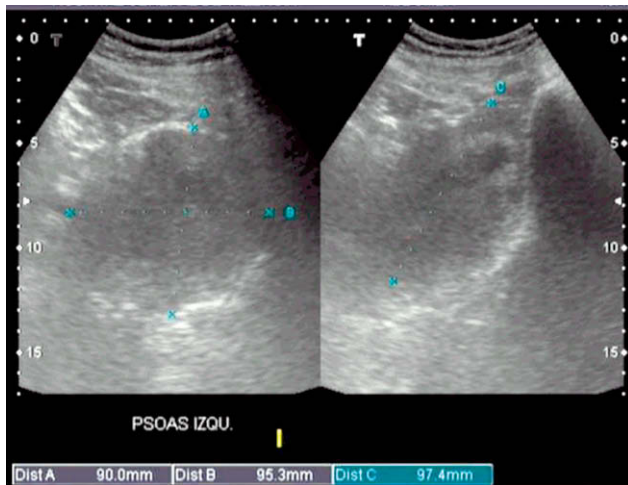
Ultrasound image showing the size of the haematoma in the left iliopsoas muscle.
